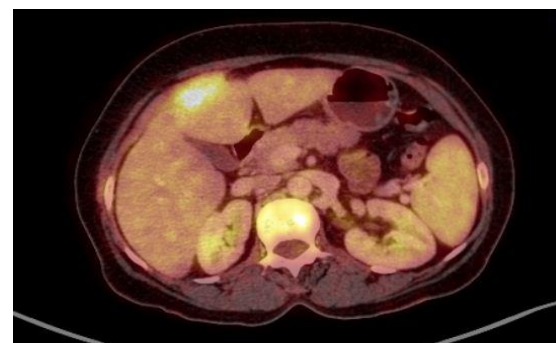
PET CT showing metabolically active subcapsular liver lesion.
